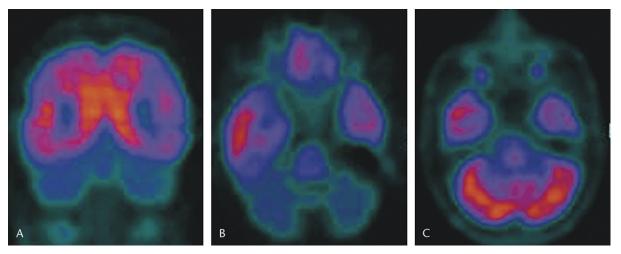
6 - (A) and (B) coronal and axial FDG PET scan in a 50-year-old heroin abuser showing a bilateral reduced cerebellar gray matter uptake. (C) Normal axial FDG PET scan.
